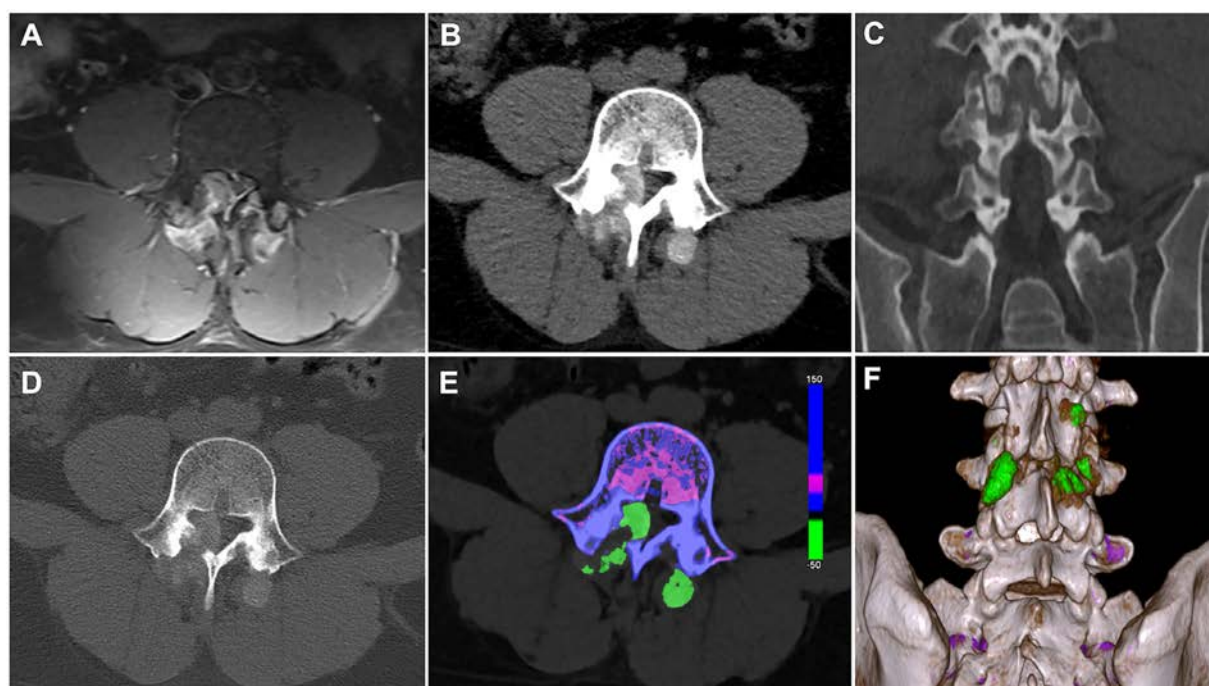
Spinal gout. (A) Contrast-enhanced magnetic resonance imaging showed multiple intraspinal and extraspinal mass lesions with obvious enhancement displacing the posterior spinal cord at the level of L3-L4, with narrowing of the spinal canal. (B-D) Conventional computed tomography (CT) depicted erosion of bilateral L3-L4 facet joints by multiple slightly hyperattenuating masses that encroached on the left neural foramen and caused marked canal stenosis. (E,F) Dual-energy CT demonstrated green colour-coded monosodium urate deposition in the intraspinal and extraspinal hyper-attenuated masses around the bilateral L3-L4 facet joints.
